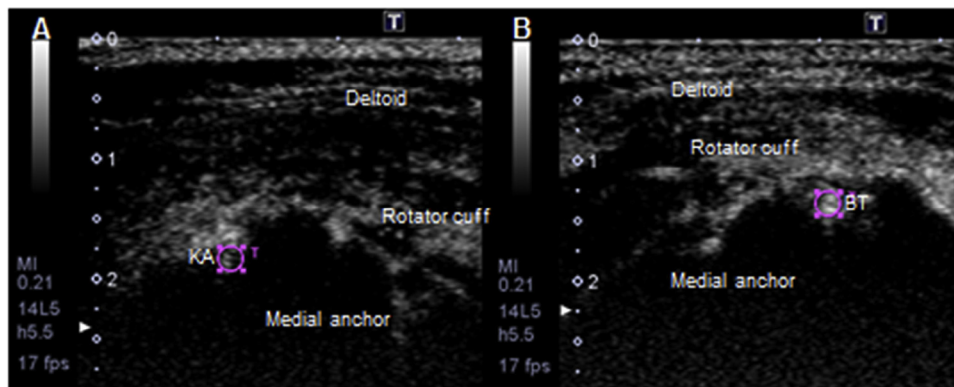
Contrast-enhanced ultrasound (CEUS) images of the repaired rotator cuff at 2 months postoperatively. (A) CEUS image of the right shoulder in the TOE group. (B) CEUS image of the left shoulder in the TO group. KA, knotless suture anchor; BT, bone tunnel.
